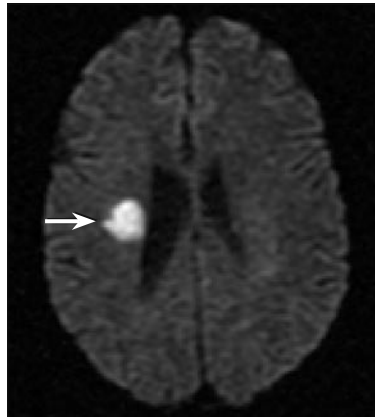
Axial diffusion-weighted MR image reveals hyperintense signal (arrow) within the right periventricular white matter compatible with restricted diffusion.
